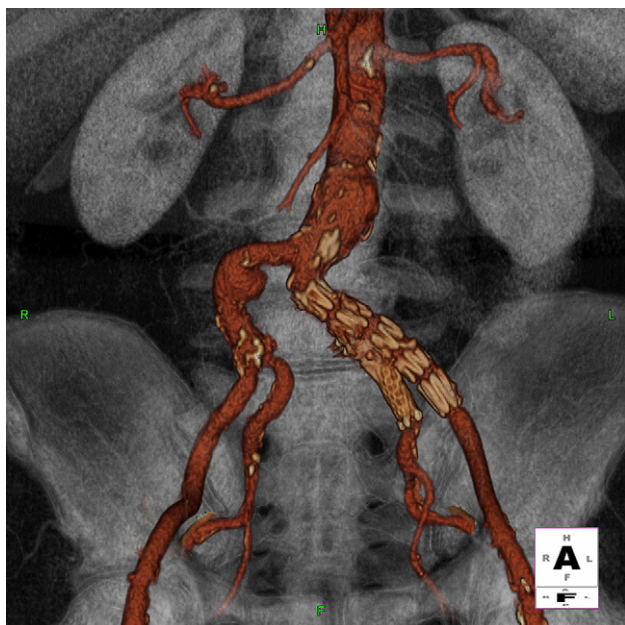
3-Dimensional reconstruction of Computed Tomography scan with TeraRecon Aquarius Workstation in a patient with iliac side-branch repair for isolated left iliac aneurysm.
